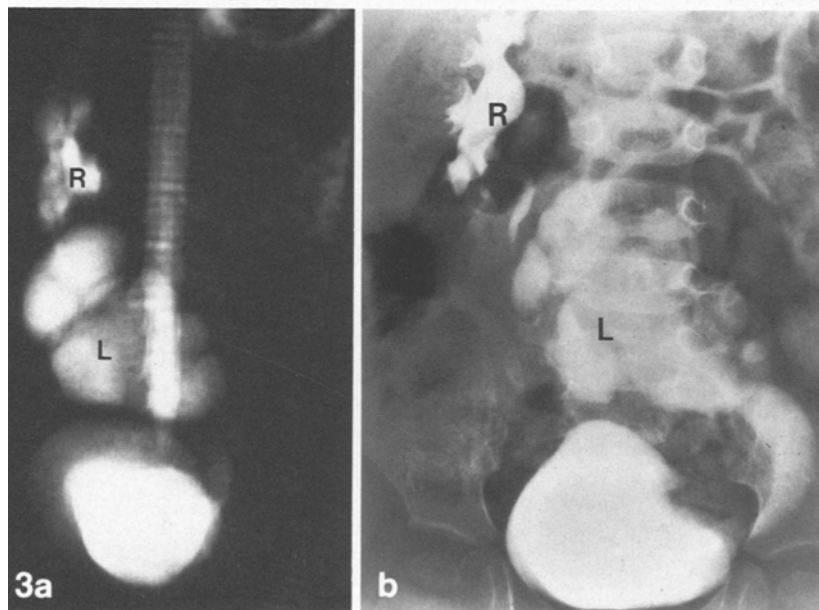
3-year-old boy with crossed dystopia of hydronephrotic “left” kidney (L) and associated megaureter (scintigraphy: 15% excretory function). The right kidney (R) shows mild dilatation due to pelviureteric obstruction (however, 85% of excretory function). Similar morphologic information of coronal RARE-MR-urography (a) and conventional excretory urography (b)
